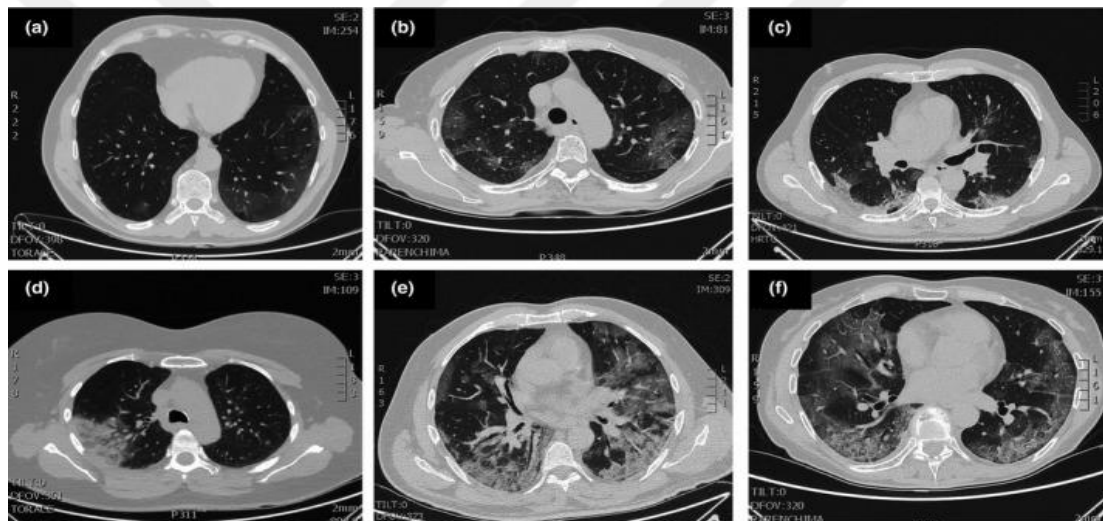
Typical patterns of COVID- 19 at CT imaging, from (a) early stage, to (f) end-stage (Pascarella *et al.*, 2020).
